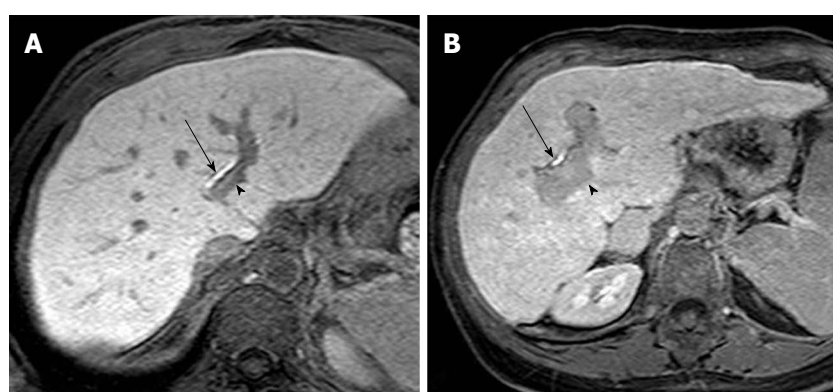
Twenty-minute hepatobiliary phase gadoteric acid enhanced magnetic resonance imaging obtained in a 67-year-old man with Child-Pugh class A hepatitis C virus-related cirrhosis (A) and in a 67-year-old woman with Child-Pugh class B hepatitis C virus-related cirrhosis (B). A: The liver shows high signal intensity compared with the portal vein (arrowhead), which shows hypointensity; B: The liver shows relative high signal intensity compared with the portal vein (arrowhead), which shows “less” hypointensity if compared with A. Visual comparison of signal intensity of the liver relative to the portal vein can be used to evaluate adequacy of hepatobiliary phase. Enhancement of bile ducts, noted in both A and B (arrows), cannot be used alone to indicate adequacy of hepatobiliary phase.
